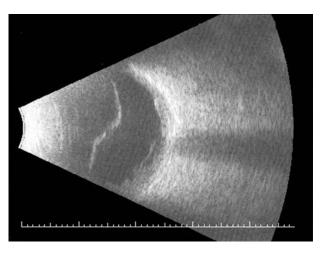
I—Ultrasound examination of left eye. Apparent choroidal elevation, vitreous opacities, and a membrane in the middle of the posterior chamber.
